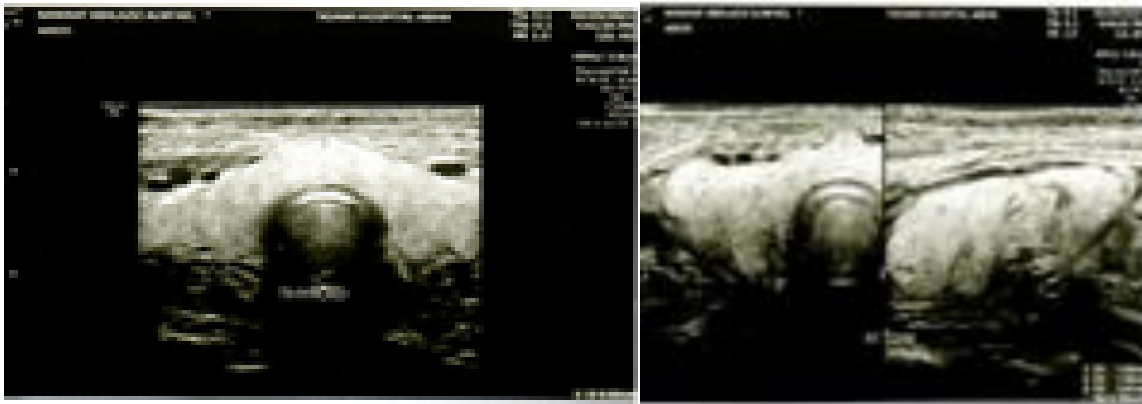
Ultrasound images of thyroid gland of 17 year-old male complaining of neck and face swelling, showed diffusely enlarged thyroid gland with heterogeneous increased echogenicity of thyroid tissue.
